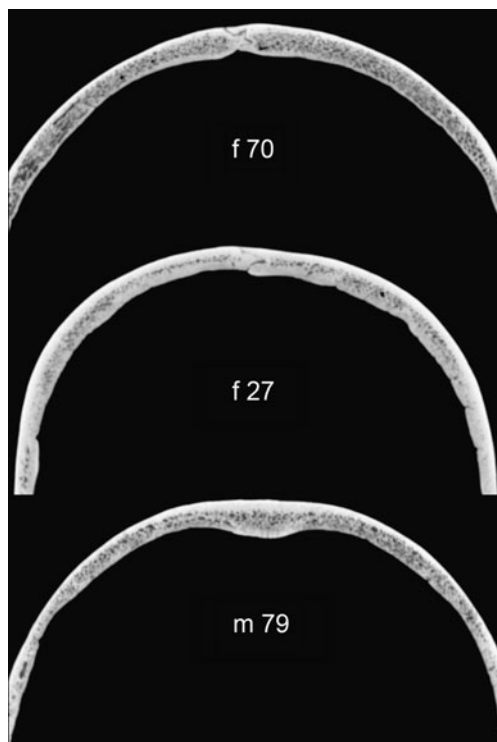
Examples of coronal skull images. The label shown below each coronal section indicates sex, *f* female, *m* male, and *age* in years. A width of 13 cm is displayed of each axial skull image. An identical “window width value” of 2,100 *H* and a “window level value” of 700 *H* were used to display the images. The values “window width” and “window level” define the visibility range and center in units of *H* within the Hounsfield unit scale of a CT image. The application of identical values of “window width” and “window level” of all skull images enables a visual comparison of the different images
